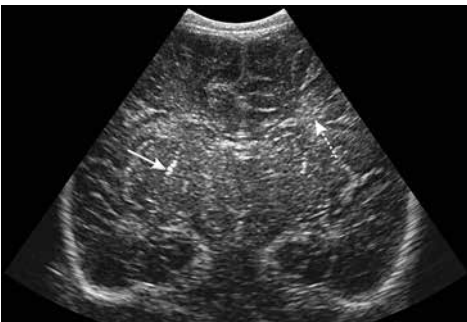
Coronal ultrasound scan in a full-term neonate (age 10 d) with viral encephalitis, showing lenticulostriate vasculopathy (arrow) and increased echogenicity of the white matter (dotted arrow).
